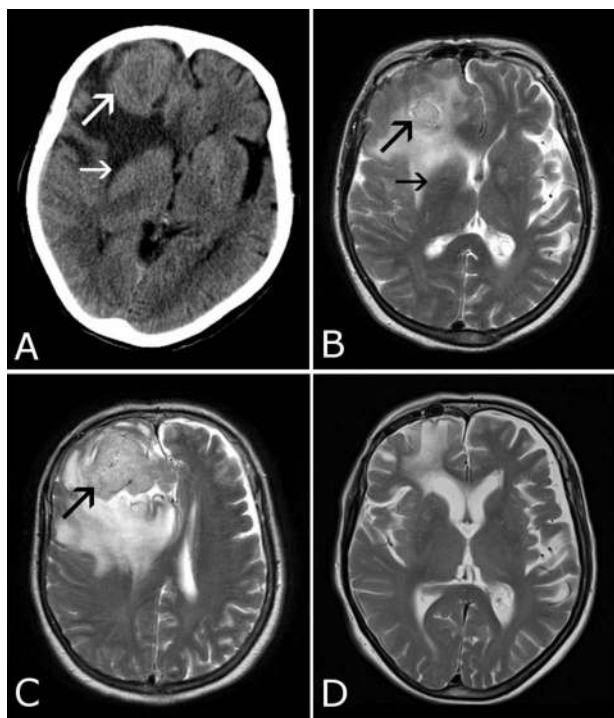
Large right frontal intracranial tumour (large arrows) with surrounding oedema, compressing and displacing the ipsilateral striatum (small arrows). (A) preoperative CT scan; (B) and (C) preoperative axial T2-weighted MRI (B) more caudal than (C); (D) axial T2-weighted MRI 3 months after surgery.
